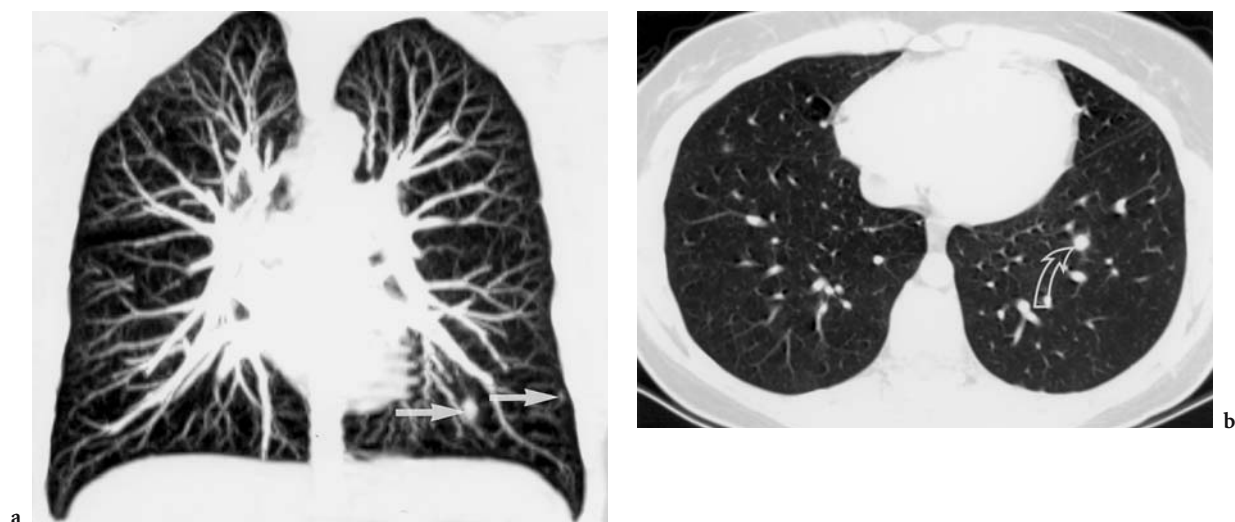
Value of 2-D multiplanar reconstruction images in lung nodule detection. a. Coronal reconstruction maximal intensity projection image shows two small lung nodules in left lower lobe (arrows). b. Axial image from original CT dataset shows the larger of the two left lower lobe lung nodules located centrally (curved open arrow). This nodule was initially overlooked on the axial image but was readily detected on the reformatted images. Centrally located nodules are more easily detected on multiplanar reformation images than on axial images (Reprinted with permission from CHOI and BOISELLE 2002)
